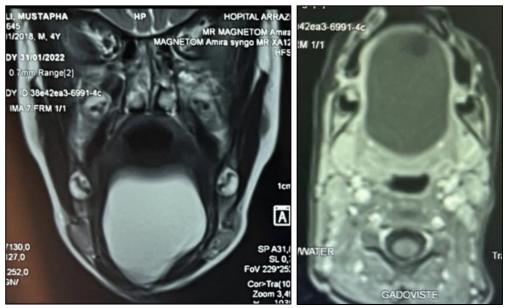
MRI image of the mass
